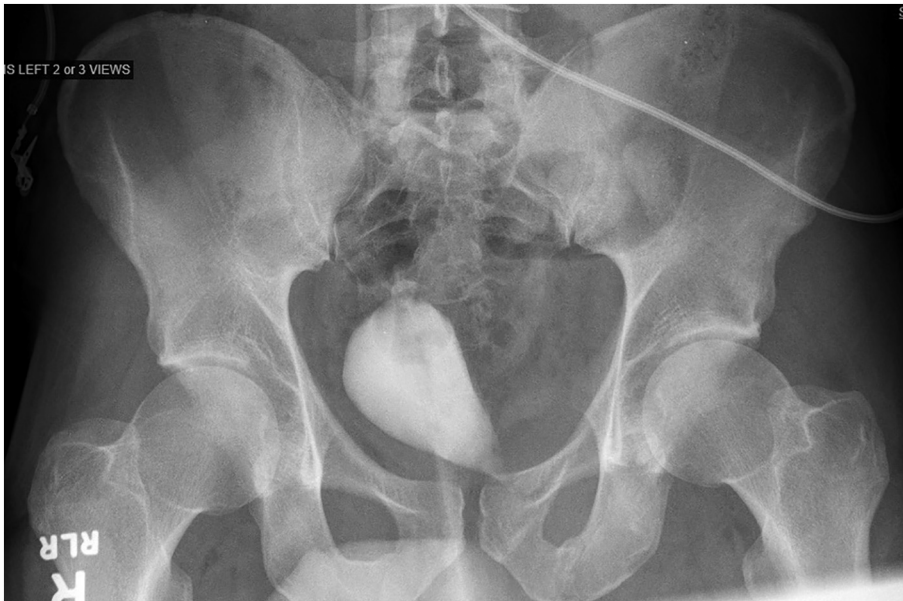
Residual contrast in the bladder shows bladder entrapment by the left superior pubic ramus fracture on this AP pelvis X-ray.
